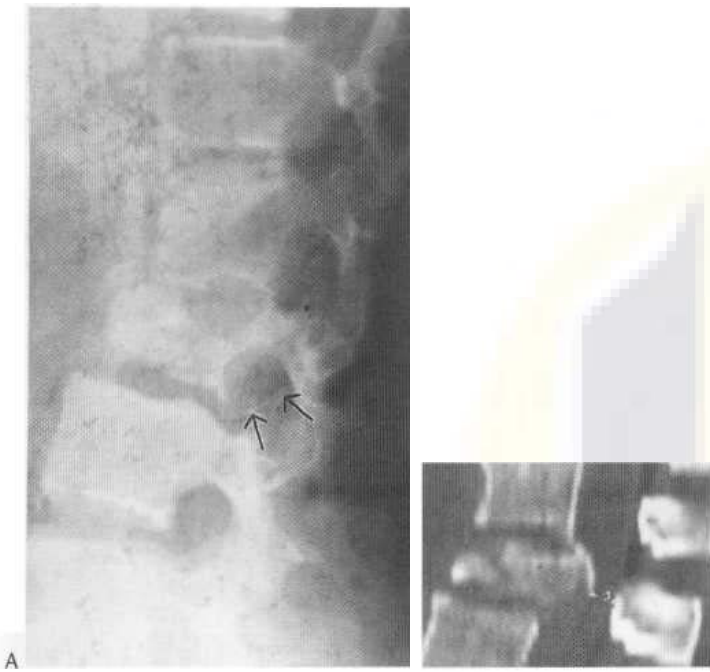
Compression fracture L2. (A) Again there is wedging and compression of L2, with evidence of body debris overlying the spinal canal (arrows). (B) CT reconstruction indicates the position of the bone fragments and narrowing of the canal.
